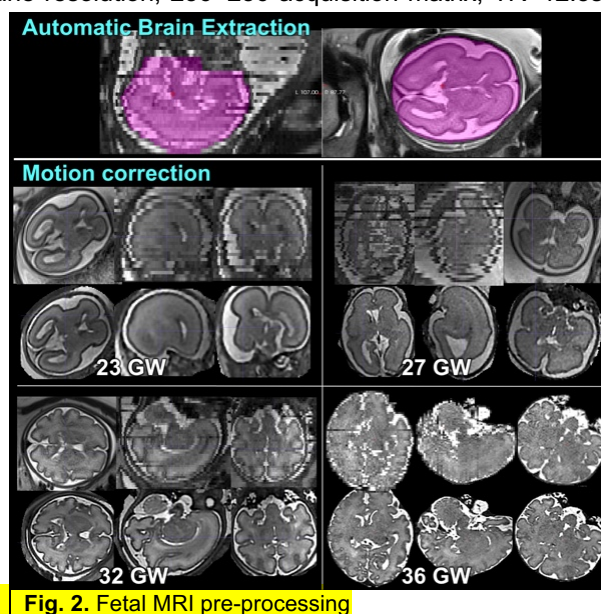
Fetal MRI pre-processing
